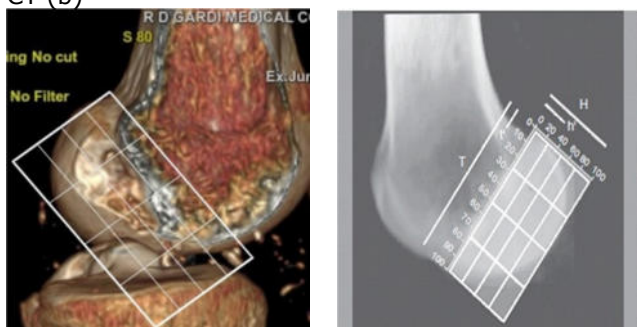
Bernard and Hertel quadrant method on 3D CT reconstruction model (a) & on sagittal section of CT (b)
